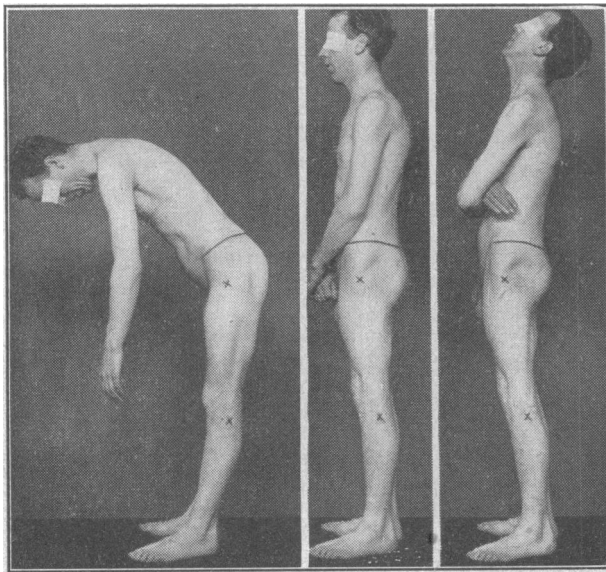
Before x-ray treatment.
